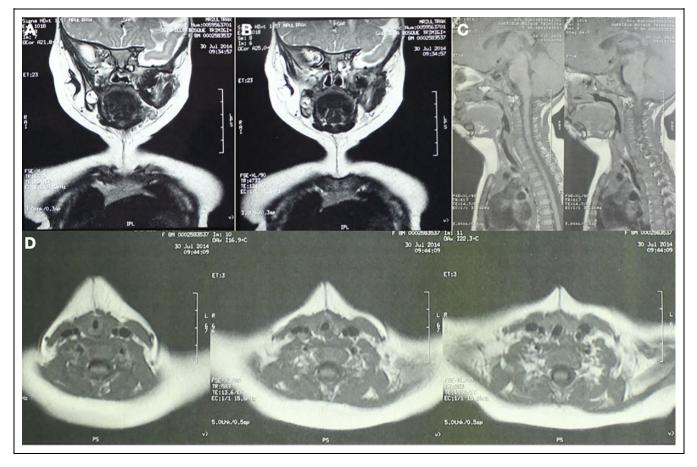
A 4.4-cm linear subcutaneous lesion of midline cervical area, extending between the chin and the thyroid's isthmus on magnetic resonance image.
